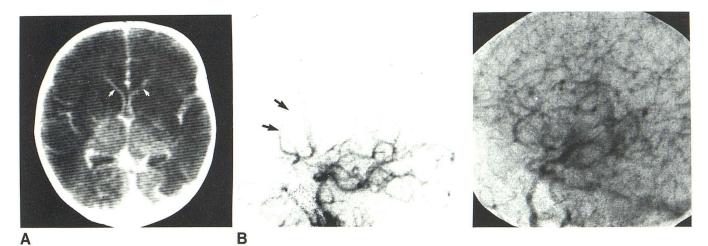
Case 2, occlusion of internal carotid artery, sagittal sinus thrombosis. A, CT with contrast shows prominent enhancement of paraventricular vessels (subependymal veins, *arrows*) and falx, suggesting collateral flow secondary to sinus thrombosis. B, DSA, lateral view, shows occlusion of internal carotid artery with no filling of middle cerebral arteries and filling of only proximal part of anterior cerebral arteries through circle of Willis collaterals from posterior circulation (*arrows*).
